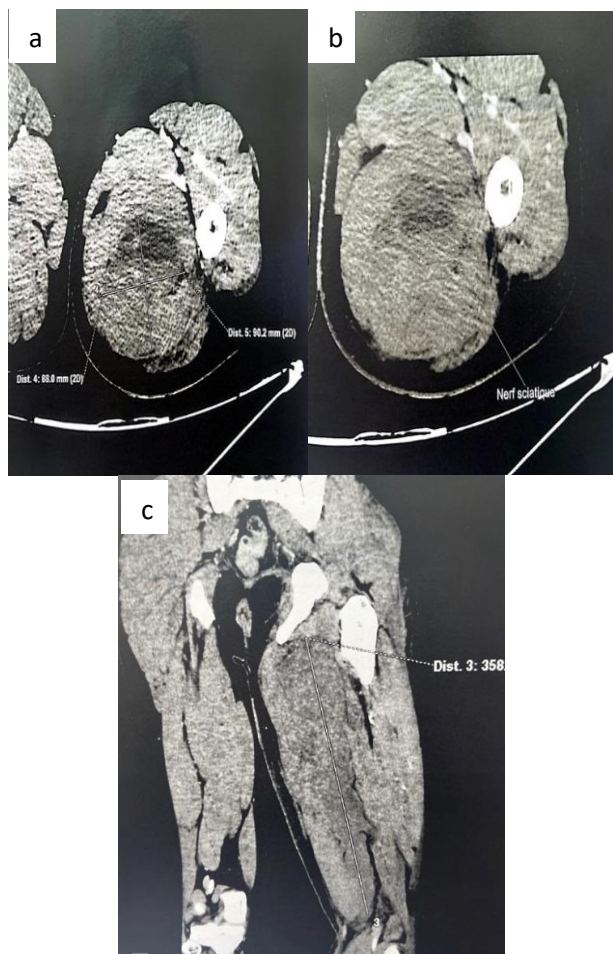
(a-c): Angio-CT scan of the lower limb showing thigh hematoma.
